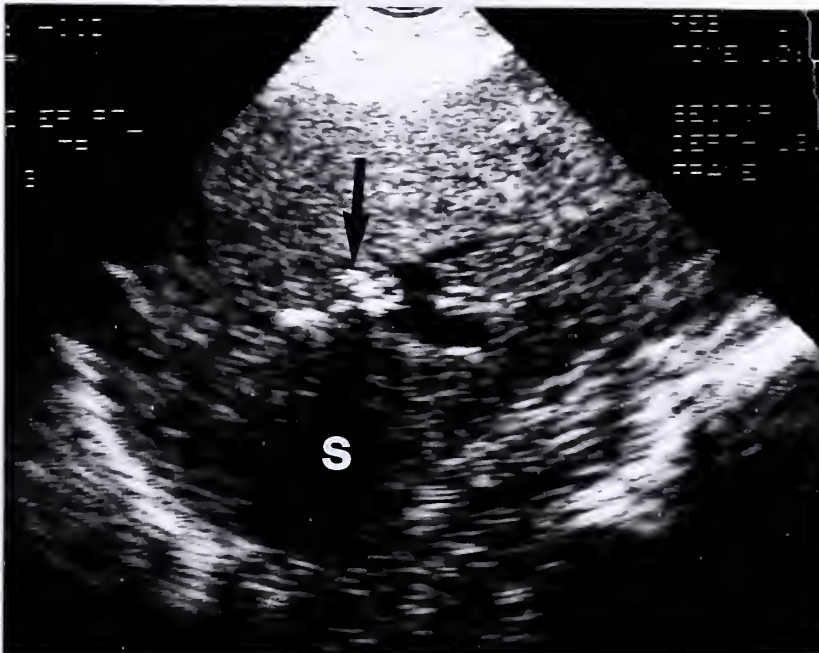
Subject #1: Ultrasound images of: (A) the gallbladder, containing gallstones [echogenic foci (small arrows) with complete acoustic shadowing (S)] in the dependent portion, and air [echogenic foci (large straight arrow) with "dirty" shadowing (curved arrow)] in the non-dependent portion; and (B) the liver, with air in the intra-hepatic bile ducts [echogenic foci (arrow) with shadowing (S)].
